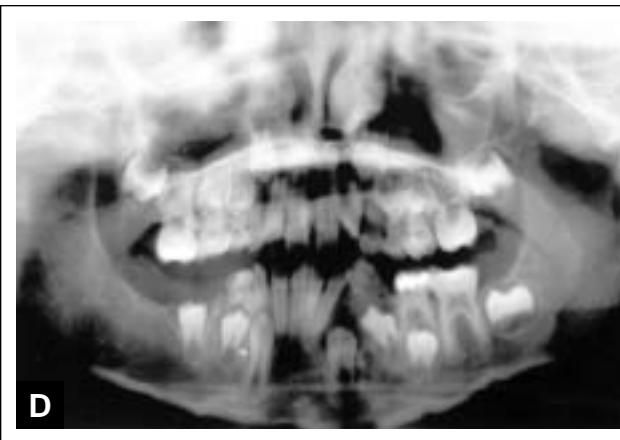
One-year post-operative panoramic radiography demonstrating good osseous healing.
